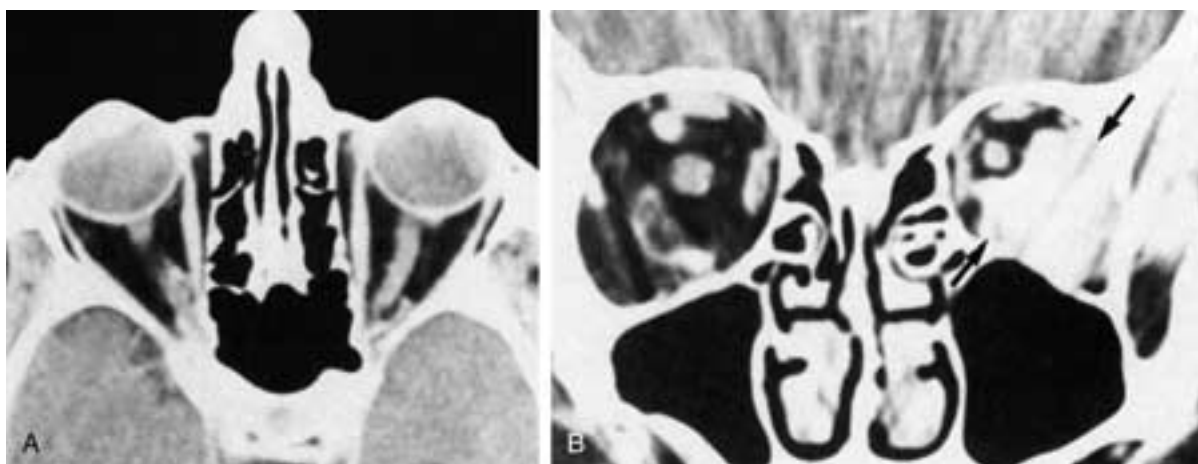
A, Orbital varix. Axial CT scan shows no obvious lesion. B, Coronal CT scan shows a large mass (arrows). (From Mafee MF et al. Orbital space-occupying lesions: role of CT and MRI: an analysis of 145 cases. *Radiol Clin North Am* 1987;25:529.)
